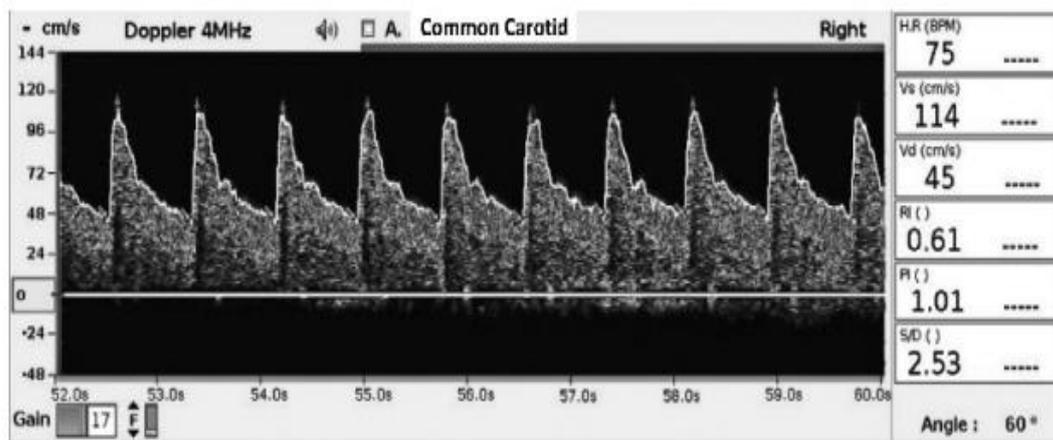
Continuous wave Doppler
